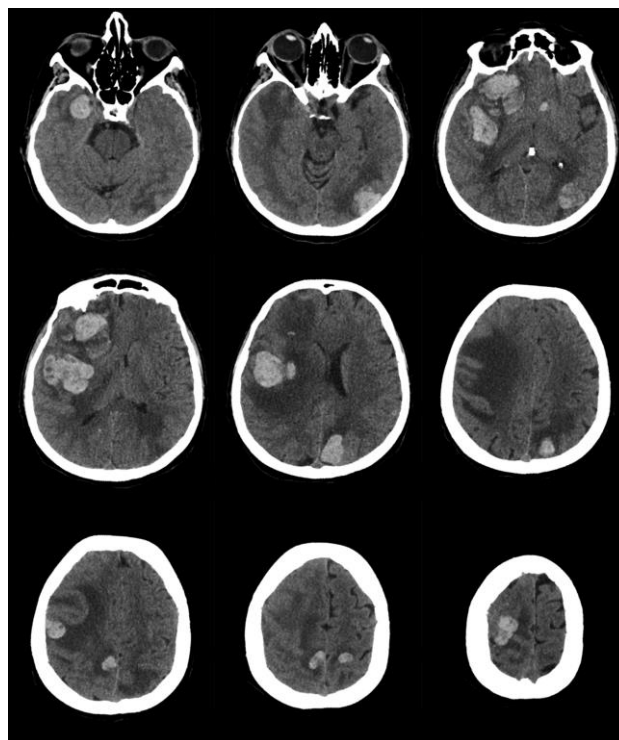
Axial CT scan shows significant hemorrhage and swelling in the frontal, temporal, and parietal lobes of the right hemisphere, with the largest lesion measuring 4x4.5 cm located in the parietal lobe. Additionally, smaller lesions with similar characteristics are observed in the left hemisphere, specifically in the parietal and occipital lobes as well as the left caudate nucleus. The edema causes partial effacement of the right lateral ventricle and a midline shift to the right by 12 mm.
